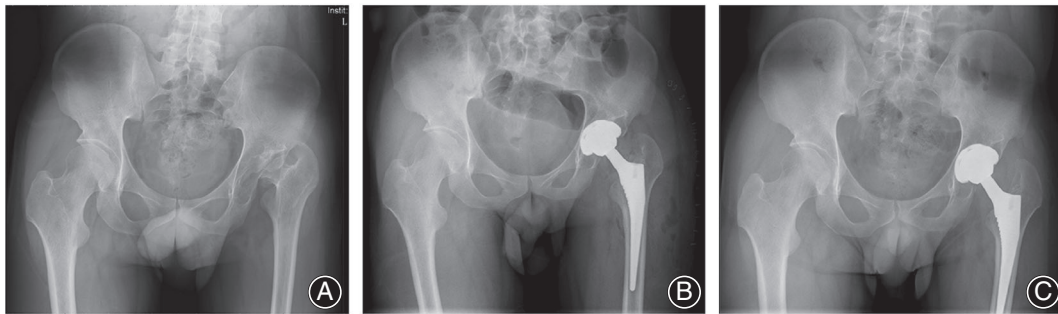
Radiographs of a 24-year-old man with osteoarthritis secondary to infection of the hip in childhood in the left hip. (A) Preoperative anteroposterior view. (B) Postoperative radiographic image at 1-week follow up. (C) Postoperative radiographic image at 7-year follow-up examination.
